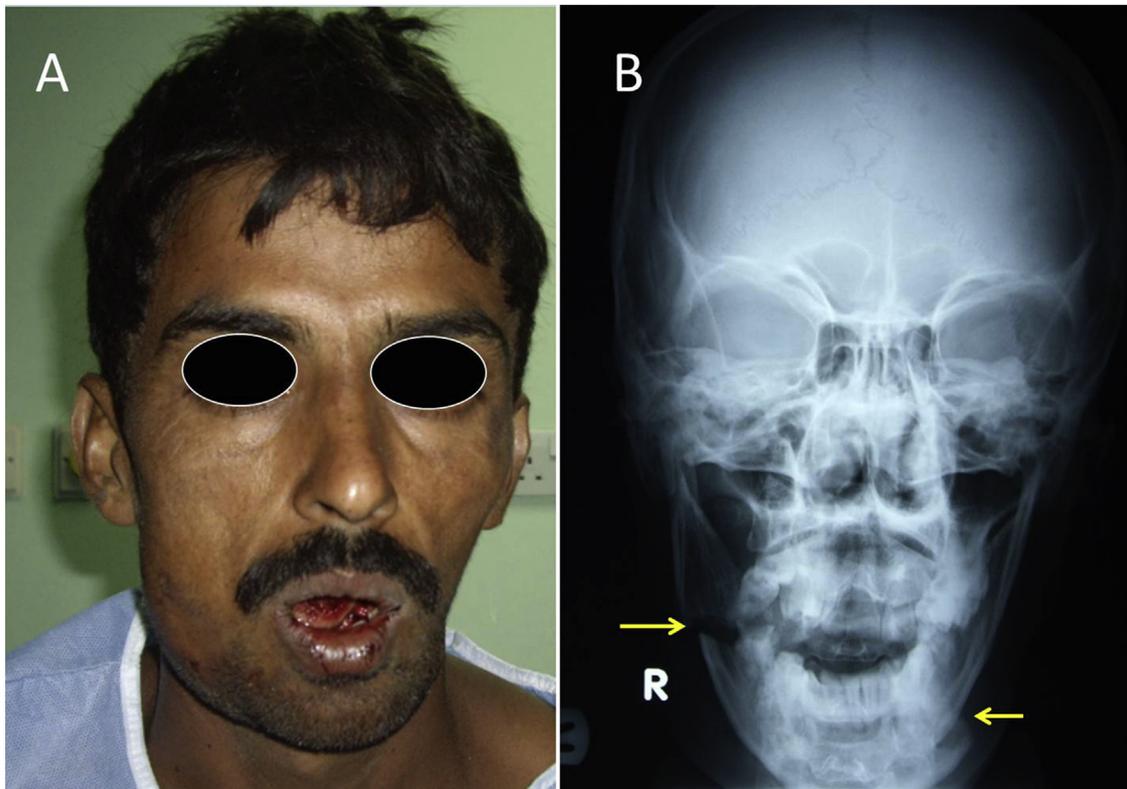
A 22-year old camel caregiver was kicked by a camel into his lower face (A). The lower face was swollen with restricted mouth opening and intraoral bleeding. Anterior-posterior skull radiograph (B) demonstrating bilateral displaced mandibular fractures (arrows).
